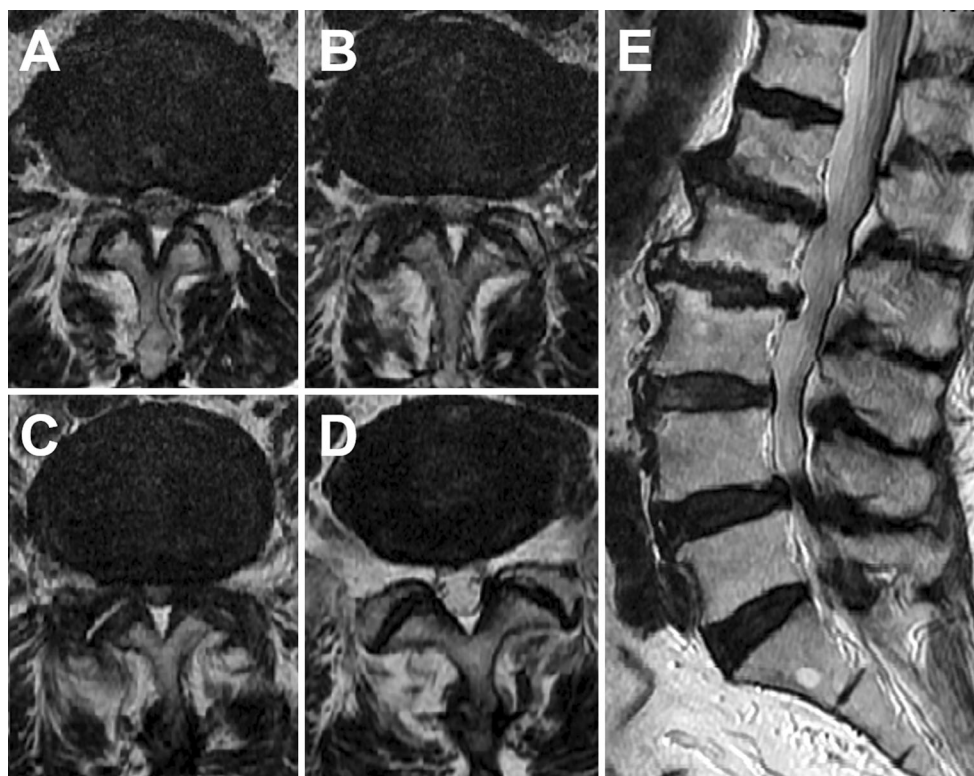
MRI (T2-weighted image) revealed lumbar spinal canal stenosis from L2/3 to L4/5. a L2/3 axial image. b L3/4 axial image. c L4/5 axial image. d L5/S1 axial image. e Sagittal image
